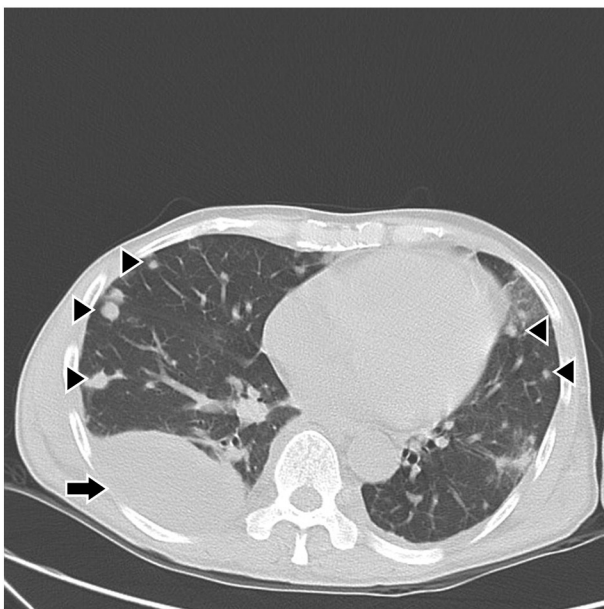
Chest CT showed lobulated pleural effusion over the right chest (arrow) and multiple nodules over both lung fields (arrowhead).
